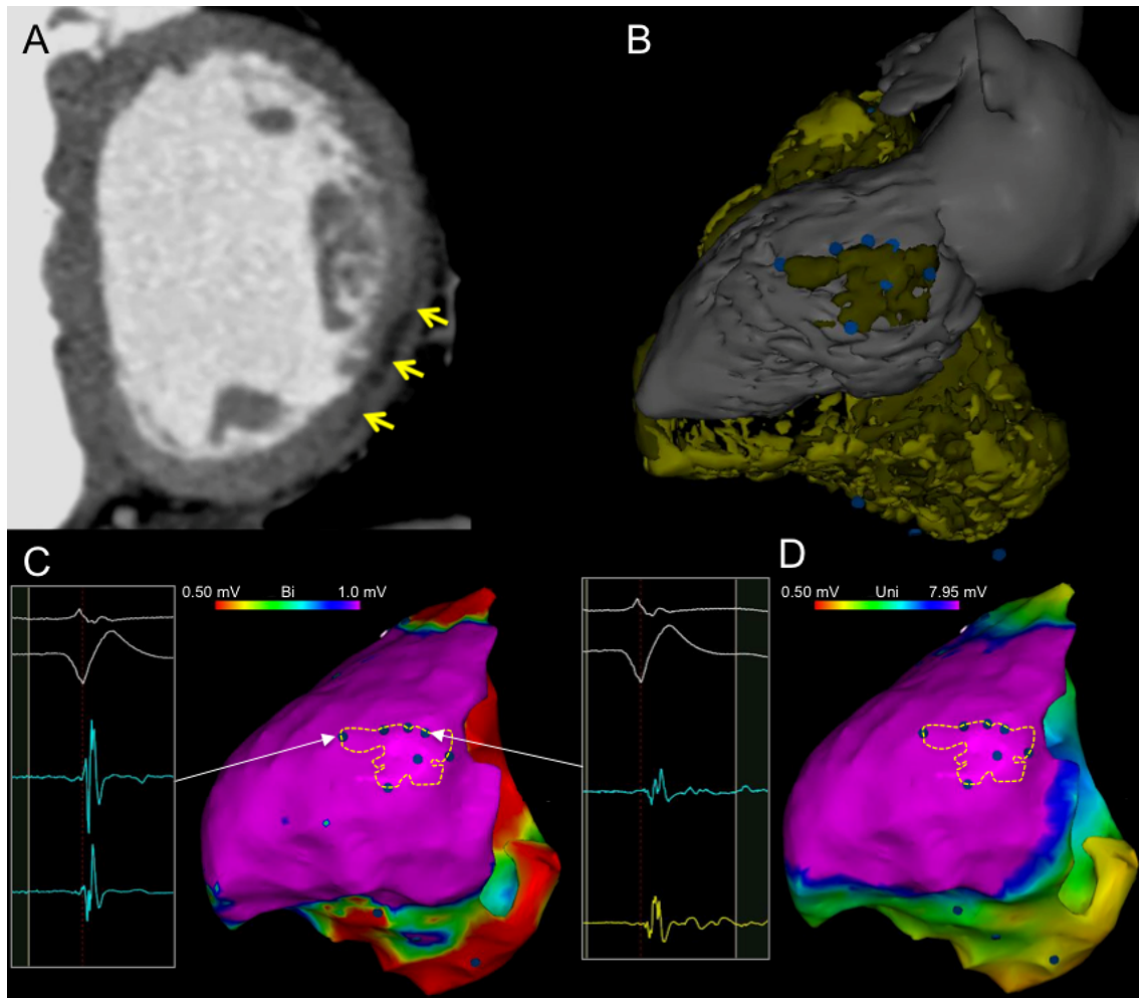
example of left-sided ARVC substrate on imaging and contact mapping. Contrast enhanced cardiac gated MDCT shows hypo-attenuation consistent with intra-myocardial fat on posterolateral LV wall (arrows in A). The 3D model derived from MDCT segmentation shows diffuse RV fat, and focal postero-lateral LV fat (yellow surface in B indicates fat). Bipolar and unipolar voltage mapping (C and D, respectively) shows diffuse low voltage on the RV, but no low voltage on the LV, including at the site of intra-myocardial fat (yellow dashed contour in C and D). Local abnormal ventricular activity is found within LV fat area (blue dots, arrows and signals in C). ARVC: arrhythmogenic right ventricular cardiomyopathy; LV: left ventricle; MDCT: multi-detector computed tomography; RV: right ventricle.
